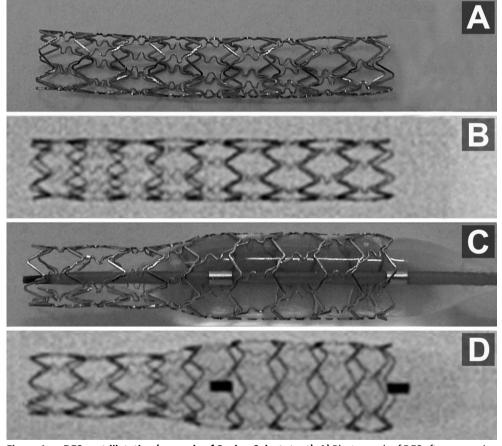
DES postdilatation (example of Cypher Select stent): A) Photograph of DES after expansion at 14 atm; B) high resolution radiographic image of A; C) photograph of partial proximal postdilatation with 5 mm non-compliant balloon at 18 atm; D) high resolution radiographic image of C.
